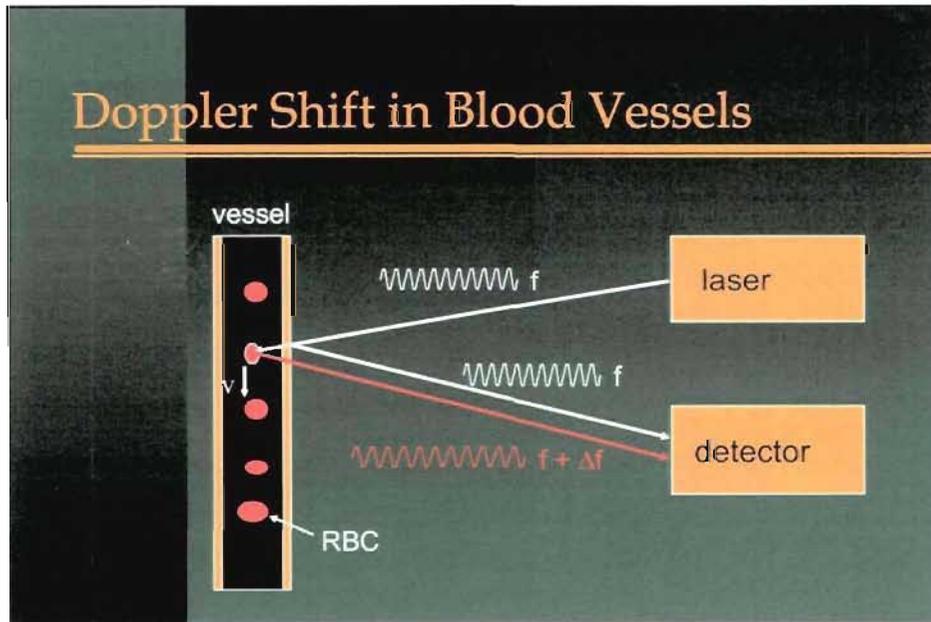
The Doppler effect is caused by a frequency shift of waves reflected by moving red blood cells (RBC). “ f ” is the original frequency “ Δf ” is the Doppler-shifted frequency.
